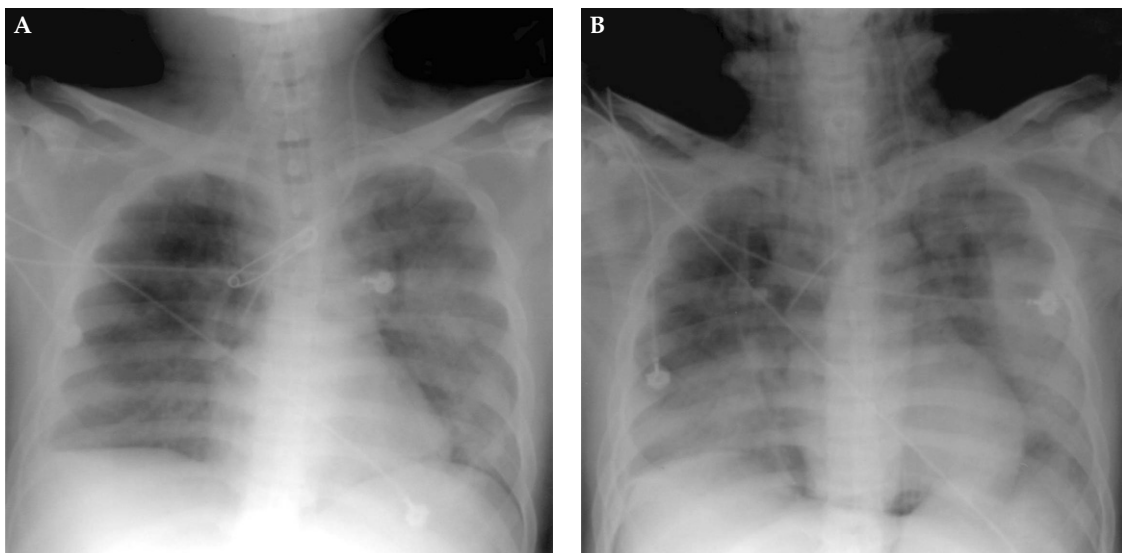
(A) Chest radiograph taken on the day before percutaneous dilational tracheostomy (PDT) showed barotrauma, presenting as subcutaneous emphysema and pneumomediastinum. (B) Chest radiograph taken immediately after PDT demonstrated marked progression of preexisting subcutaneous emphysema and pneumomediastinum.
